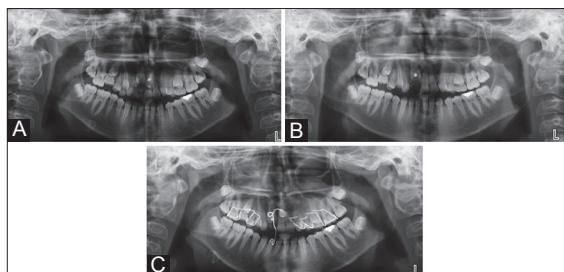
A: Impacted supernumerary tooth prevented the eruption of right upper central incisor of 13-year-old girl. B: Panoramic radiography taken after 2-months postoperative follow-up period. Orthodontic button was cemented on upper right central tooth at the time of the surgical removal of the supernumerary teeth for orthodontic treatment. C: Eruption of right upper central tooth to the original position can be clearly seen on panoramic radiography taken after 7-months postoperative follow-up period
